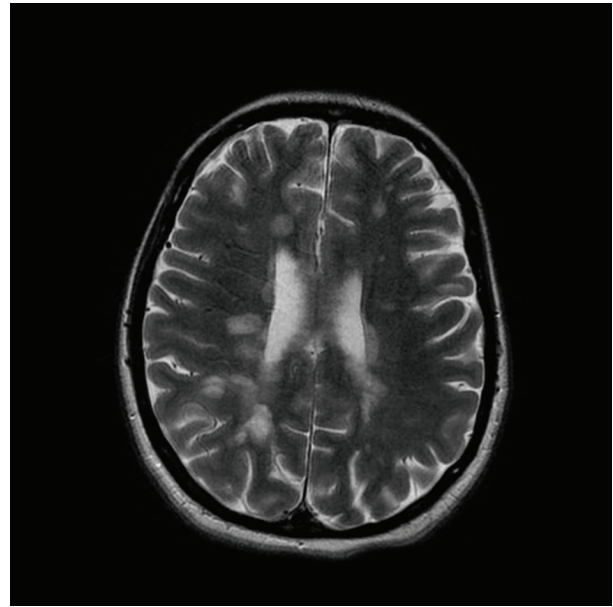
MRI findings in line with MS
